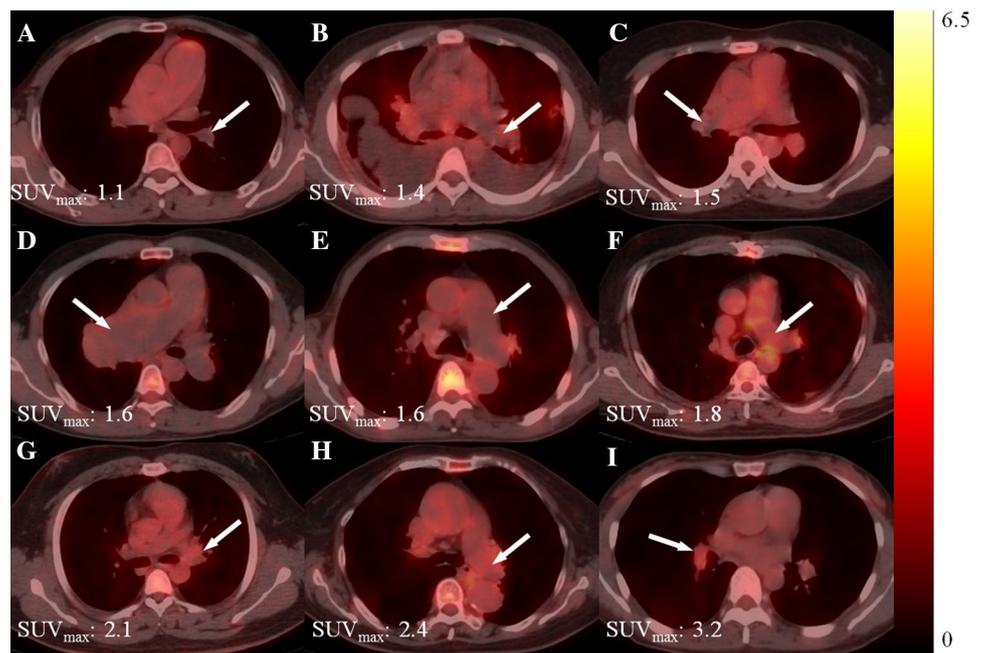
^{18}F -FDG PET/CT images of our cases of PTE (arrows indicate thrombus)
